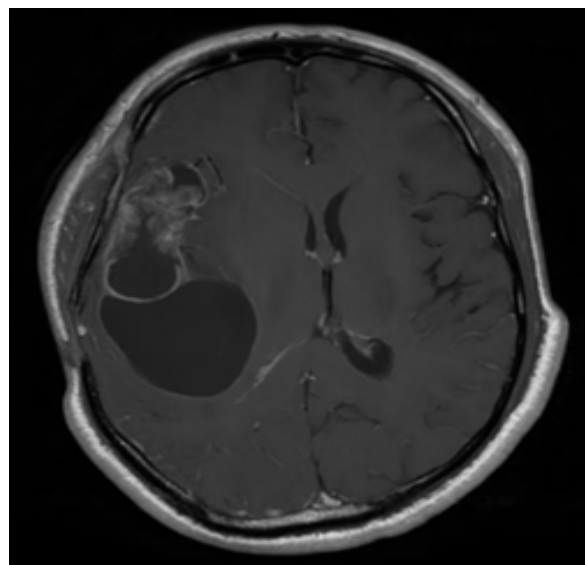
Axial section of T1 post-contrast MRI brain showing heterogeneously enhancing cystic cum solid intra-axial lesion in the right fronto-temporal region. The lesion is causing effacement of ipsilateral lateral ventricle. Previous surgery scar can be seen on scalp. The lesion had been reported as Glioblastoma grade IV at time of first surgery.
